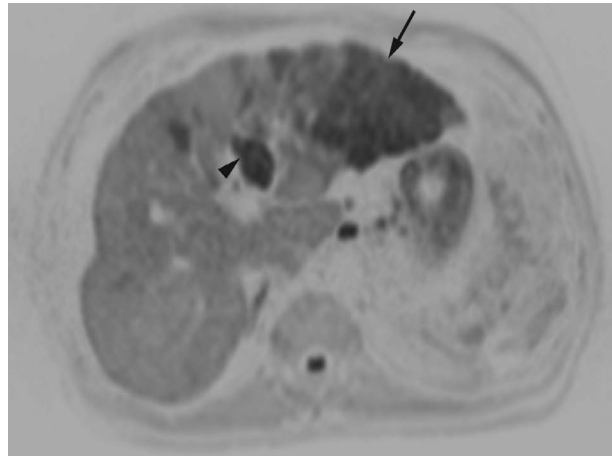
I-HCC. Annotated. Liver. MRI. DWI (inverted grayscale). b=500. Axial plane. An arrow points to the area of restricted diffusion of the left hepatic lobe lateral segment's I-HCC. An arrowhead points to tumor thrombus in the left portal vein.
